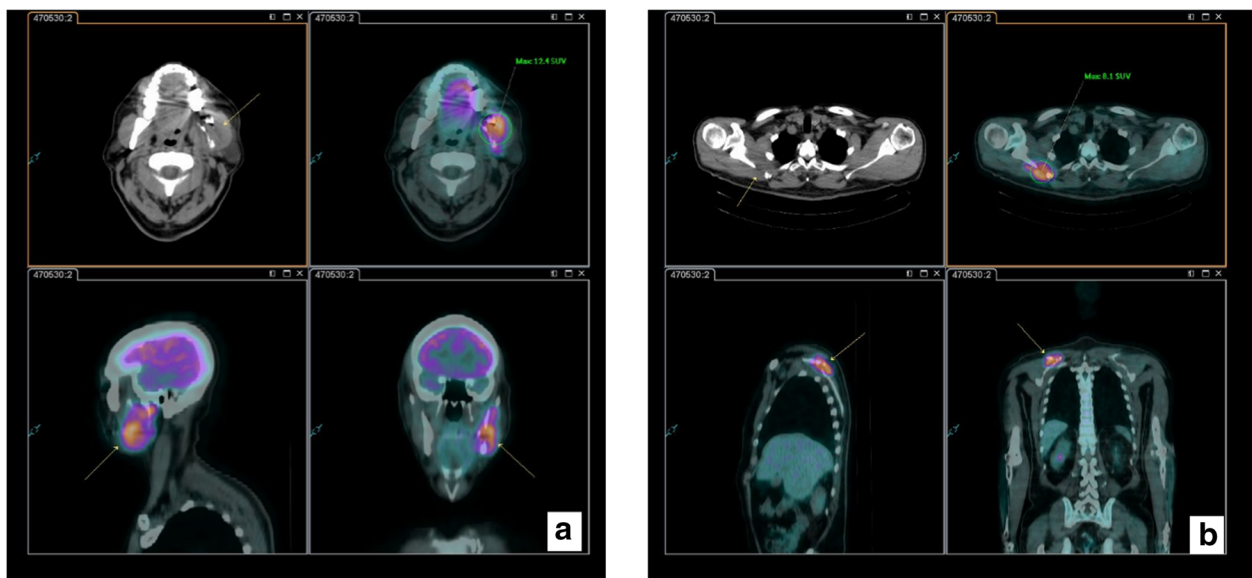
a PET-CT with uptake of 12.4 SUV in the left mandible. b PET-CT with uptake of 8.1 SUV in the clavicle right
